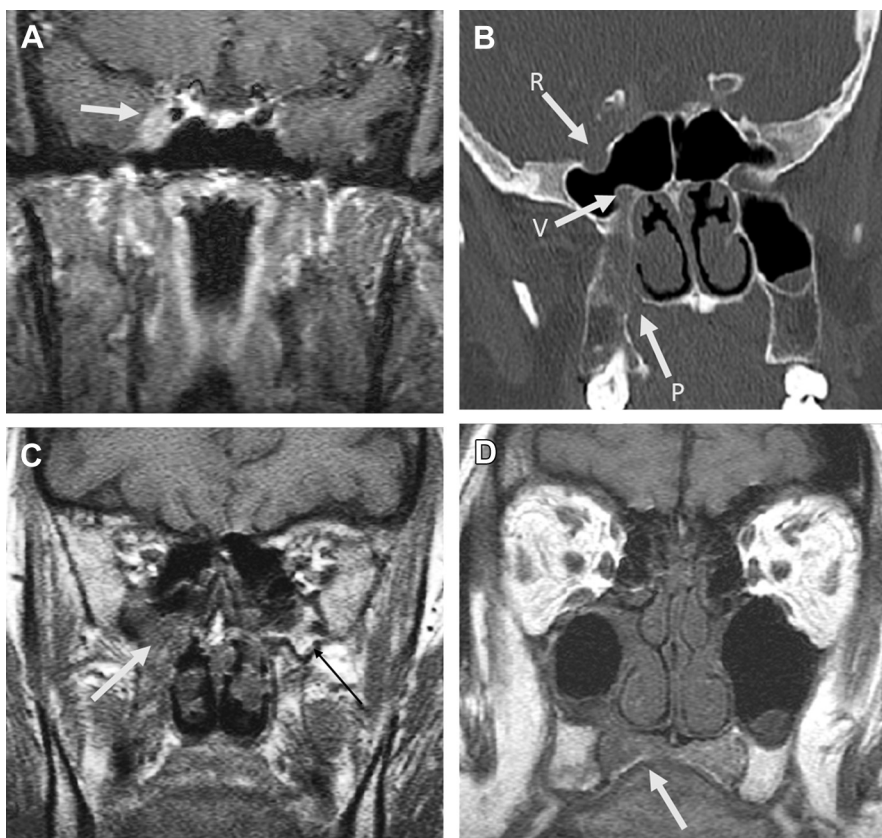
A 56-year-old woman presented with diplopia. Coronal T1W image (A) shows a right cavernous sinus mass (arrow). Coronal CT (B) shows enlarged foramen rotundum (R), vidian canal (V), and greater palatine nerve canal (P) indicating PNS. Coronal unenhanced T1W MR image (C) shows effacement of the fat signal in the right PPF (white arrow) with preservation of fat signal in the left PPF (black arrow). A clinically occult tumor is seen in the right hard palate (arrow in D) which was shown to be adenocystic carcinoma arising from minor salivary gland.
